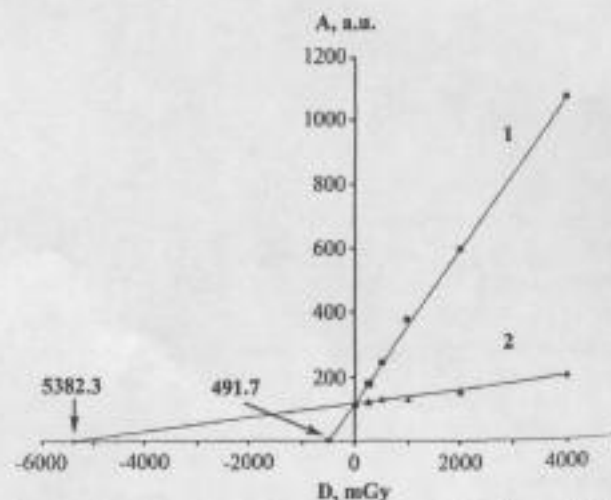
presents calibration straight lines of enamel samples of buccal and lingual sides of one tooth, in which the dose was formed by x-rays with the applied dose of 500 mGy. The dose load was assessed by calibration straight line 2 with the help of additional gamma irradiation, and by line 1 with the help of additional x-ray irradiation. As seen from this figure, the dose calculated by line 2 was equal to 5,382.3 mGy, i.e., it was higher than the applied dose by an order of magnitude. At the same time, the dose calculated by line 1 was equal to 491.7 mGy, i.e., it practically coincided with the applied.
